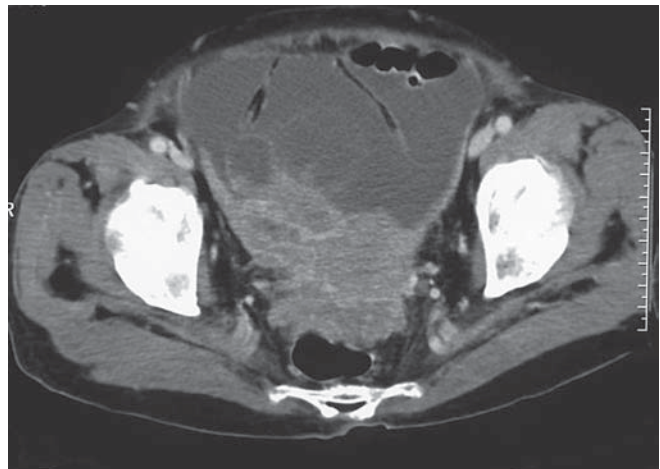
Abdominal computed tomography shows a giant mass with cystic lesions in the Douglas pouch
